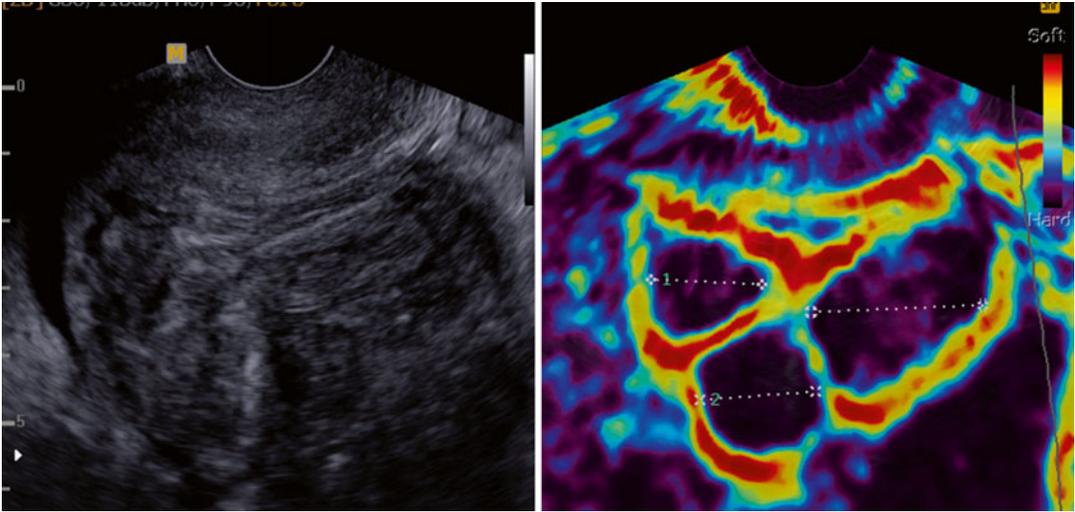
Uterus with three fibroids visualized by elastography and greyscale ultrasound
